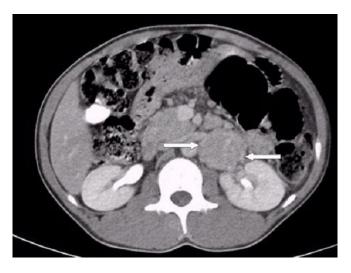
Contrast enhanced CT image in the portal venous phase showing an heterogeneously enhancing mass in the left renal hilum measuring $\sim 2 \times 2 \text{ cm}$ (white arrows).
